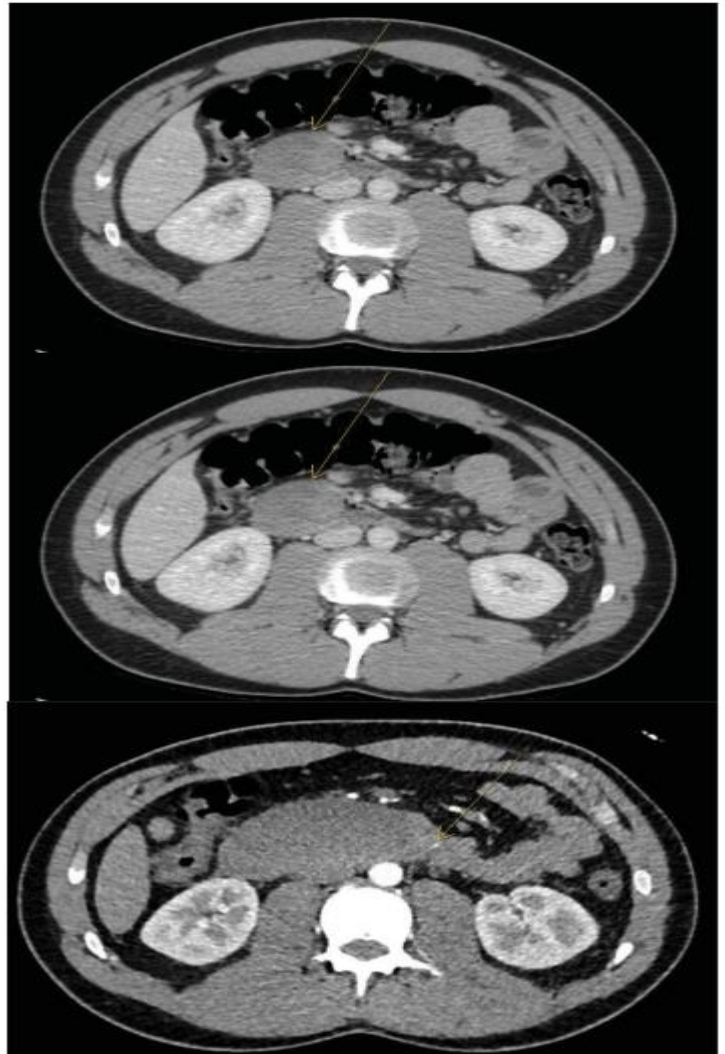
CT abdominal/pelvic images on days 1 and 3 showed increased size of the duodenal hematoma, while a CT angiogram on day 5 revealed a focal area of active extravasation.
